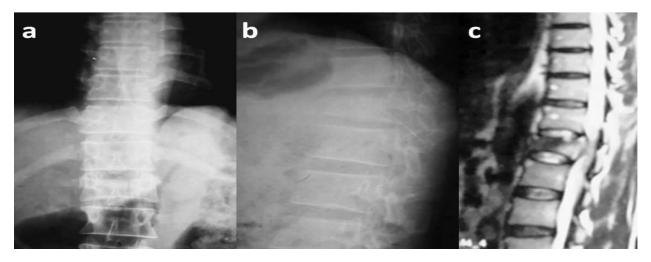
Anteroposterior and lateral radiograph of thoracolumbar spine of a 35 year old male patient showing fracture of L1 vertebra. The MRI (Image "c") also showing the compression of the spinal cord at the level of fracture.
